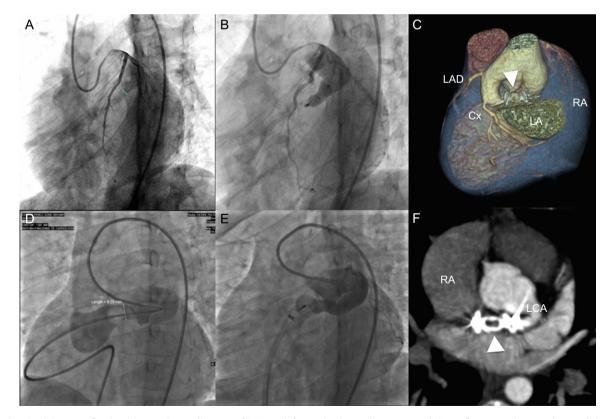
Patient 1: A) Coronary fistula with a maximum diameter of 6.5 mm; left anterior descending artery and circumflex artery show no abnormalities. B) 10-mm Vascular Plug IV in the fistula. C) Cardiac computed tomography angiography volumetric reconstruction with exclusion of the left atrium shows a properly positioned device and absence of flow through the fistula (arrowhead). Patient 2: D) Coronary fistula with a maximum diameter of 8.29 mm occluded by a pulmonary catheter, with preserved flow to the left main coronary artery. E) Deployment of the device through a retrograde approach. F) Computed tomography angiography maximum intensity projection in a paraxial view depicts absence of residual shunting and adequate placement of the device (arrowhead). Cx: circumflex artery; LA, left atrium; LAD, left anterior descending artery; LCA, left main coronary artery; RA, right atrium.
